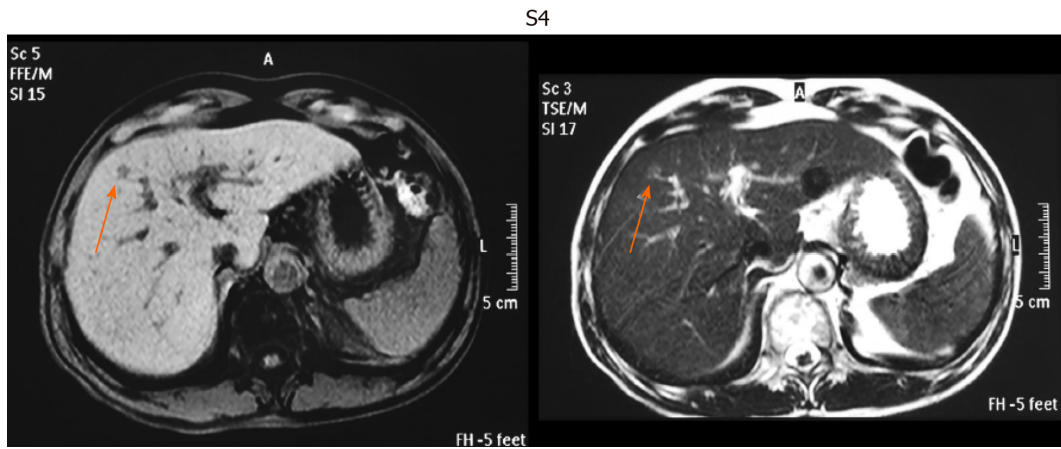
Representative image of very small hepatocellular carcinoma by unenhanced magnetic resonance imaging. Hepatocellular carcinoma in S4 segment. T1-weighted image (left, light dark spot). T2-weighted image (right, light white spot).
